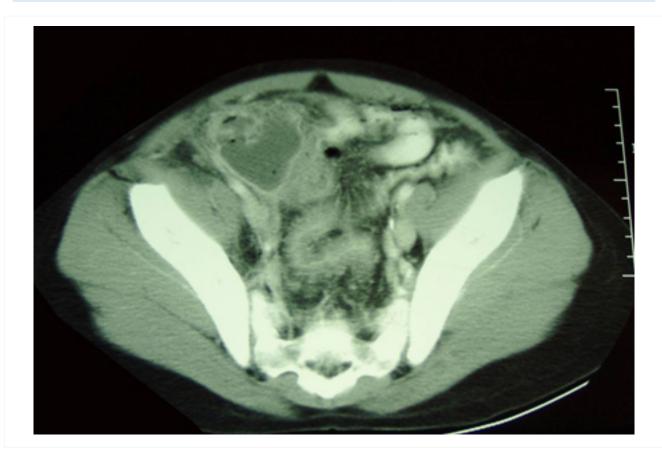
CT scan demonstrating intra-abdominal abscess consistent with perforated appendix From the collection of Dr KuoJen Tsao; used with permission
